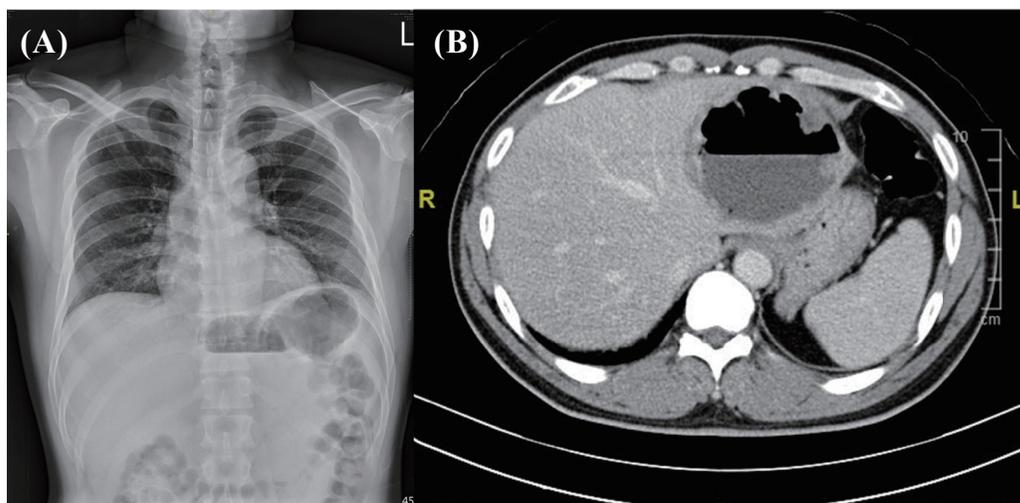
Abdominal image: (A) X-ray revealed air accumulation over the left upper quadrant of the abdomen (B) computed tomography revealed a huge abscess that was 8 cm in diameter over the left lobe of the liver.
